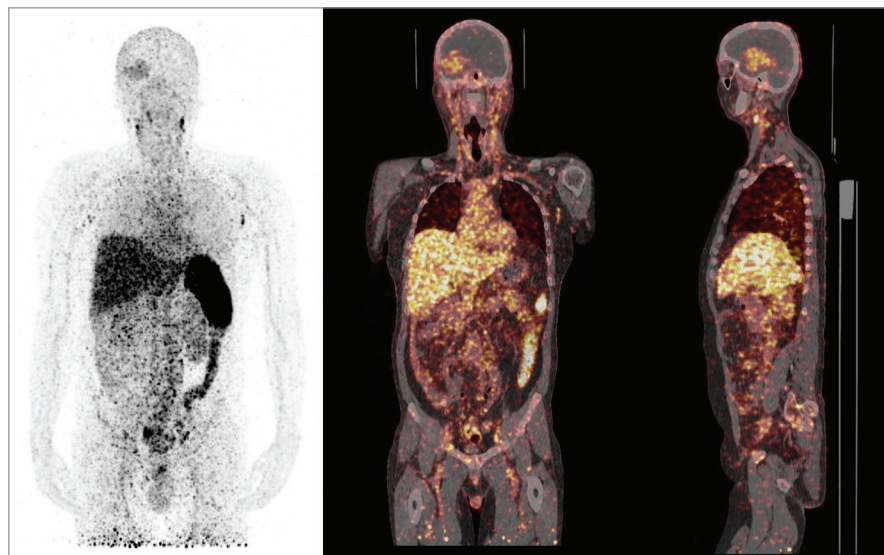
Whole-body MIP (left) and PET/CT (middle & right) of [⁸⁹Zr]Zr-atezolizumab (ca. 37 MBq, co-injection of 10 mg of unlabelled atezolizumab) in a patient with GBM at 72 h post-injection showing uptake of the imaging agent in the brain (lesion), in the liver (clearance), and in PD-L1-expressing lymphoid tissues (e.g., spleen and lymph nodes). The studies (NCT05235737) were performed at Maria Skłodowska-Curie National Research Institute of Oncology in Gliwice, Poland. Images: courtesy of Prof. Gabriela Kramer-Marek, MSCNRI, Gliwice, Poland and the ICR, London, UK.
